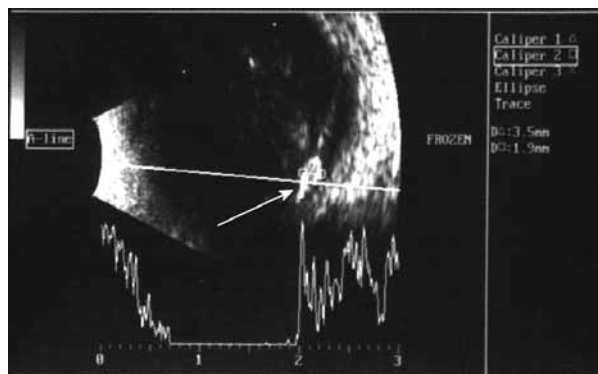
B-scan ultrasound of an intraocular foreign body (arrow) embedded in the retina.
